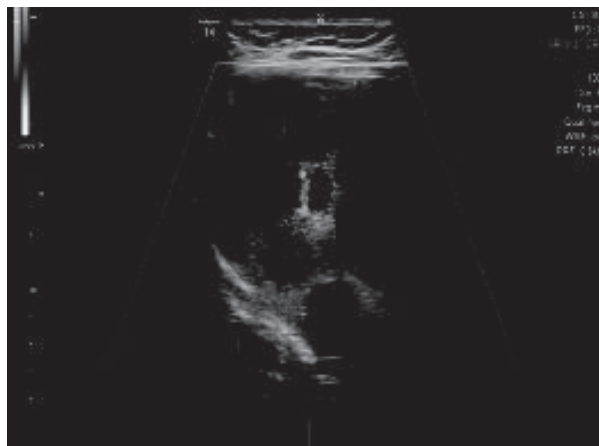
Showing Ultrasound image of a hypoechoic lesion having multiple anechoic areas within it.
